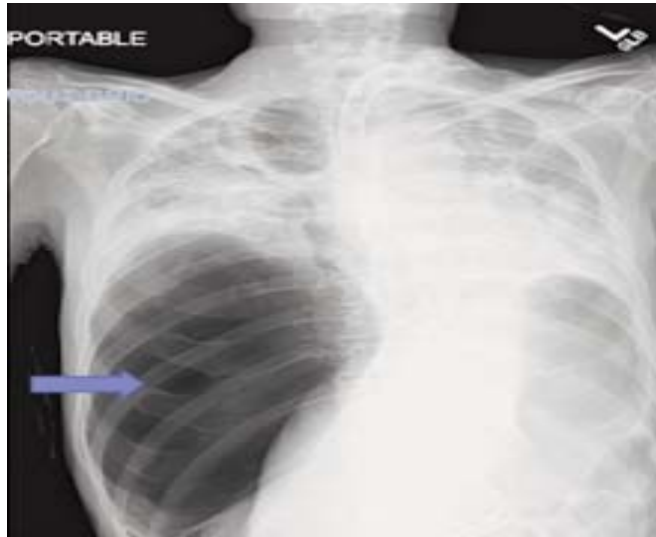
Chest X-ray with arrow pointing at large pocket of air in right upper quadrant
